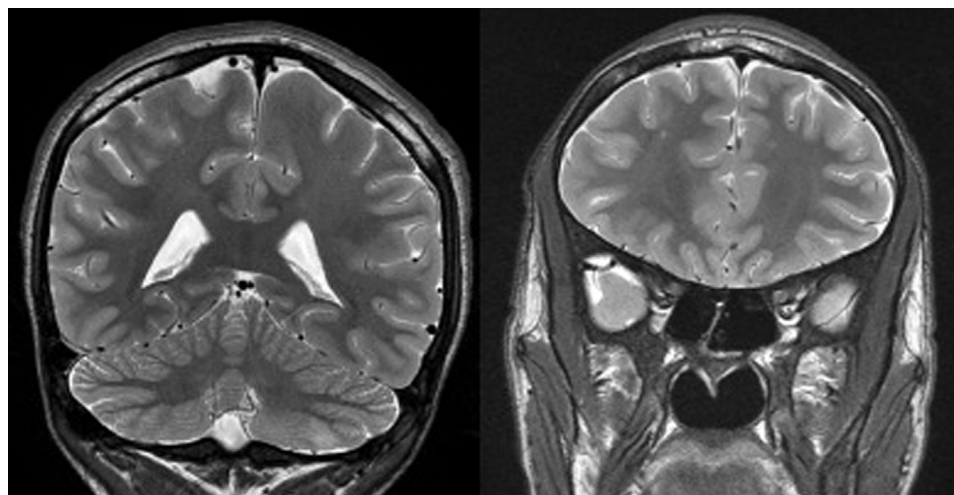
Coronal T2-weighted imaging depicting hyperintense areas in the calvaria, compatible with bone infarction, adjacent to the previous collections.
